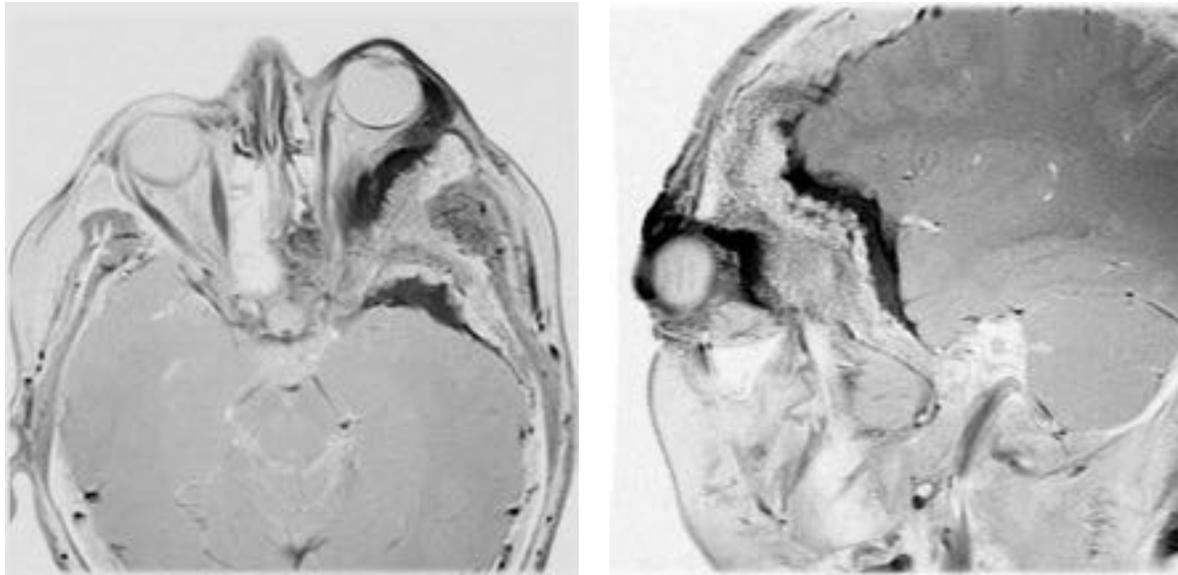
(A) Axial and (B) sagittal contrast-enhanced T1-weighted magnetic resonance imaging shows the widespread dural involvement and the intraorbital, frontal, and temporal fossa extensions of tumor. All figures are property of the Department of Neurosurgery, The University of Texas M.D. Anderson Cancer Center and are used with permission.
